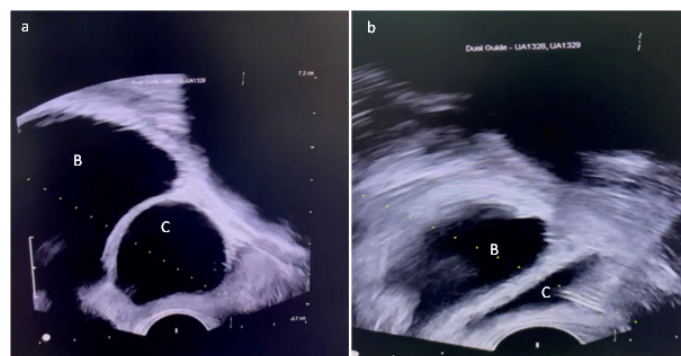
Sagittal view of transrectal ultrasound before (a) and after (b) transrectal needle aspiration of cystic lesion (C) on the posterior of the bladder (B). It was observed that the cystic lesion shrunk and disappeared after aspiration
